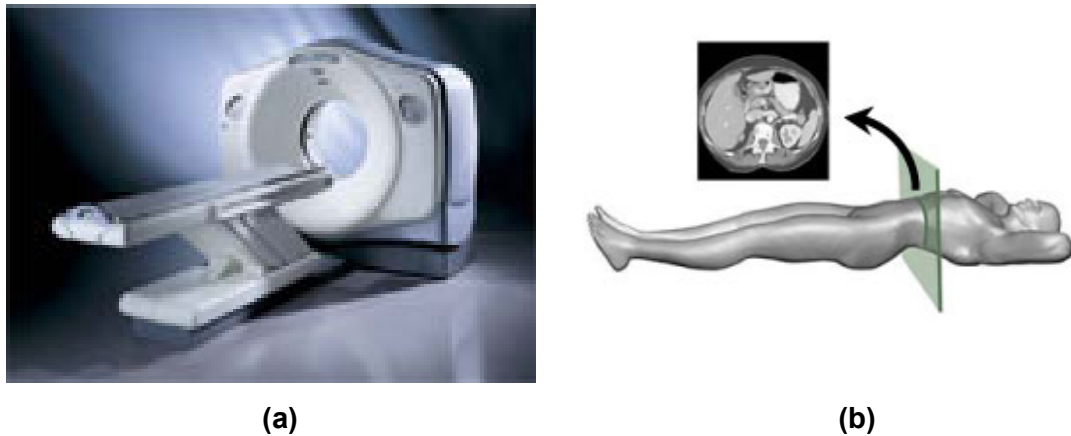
(a) Computed tomography (CT) scanner and (b) CT slice concepts
